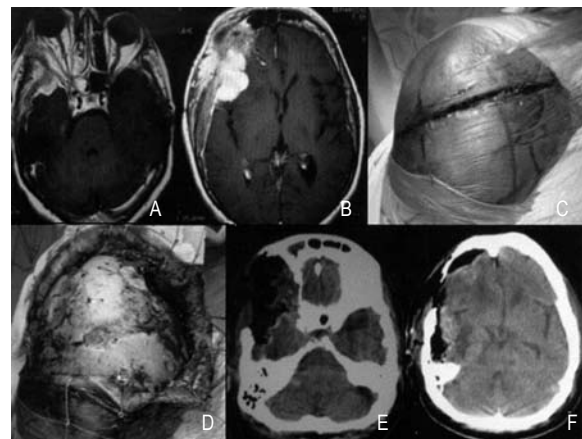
This 59 year-old female patient with a prior surgery 10 years before, presented with visual loss and proptosis. A, B: The MRI demonstrated an en plaque meningioma. C, D: The patient was submitted to surgery. E, F: The lesion was resected.
